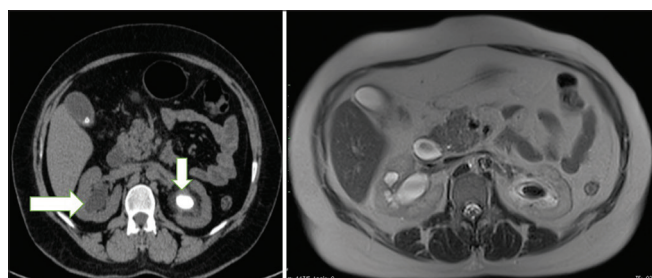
Axial non-contrast computed tomography image (left) shows hydronephrosis in right kidney with large calculus in left renal pelvis with secondary hydronephrosis (white arrows) with similar findings in corresponding T2W axial magnetic resonance image (right)
